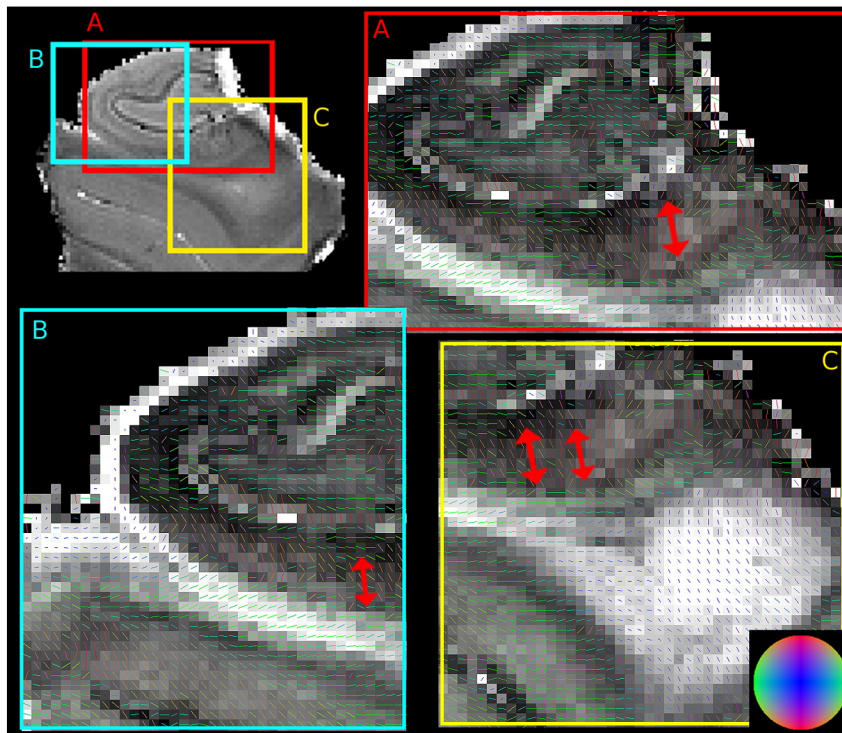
Microstructural organization of the temporal lobe estimated by diffusion MRI overlaid onto fractional anisotropy maps. Grayscale on top left is the average diffusivity (AD) map displaying the boundaries of the regions displaying fiber orientations obtained by method of Wishart diffusion displacement probability maxima (A–C). (A) Red box displays the hippocampal regions, such as the subiculum and CA1, with largest maxima of water displacement in the direction to and from the dentate gyrus (parallel to red arrow) and the alveus. (B) Turquoise box displays the infra-subicular portion of the alveus traversing horizontally toward the entorhinal cortex. (C) Yellow box displays the angular bundle region with dominant orientation pointing anterior posterior.
